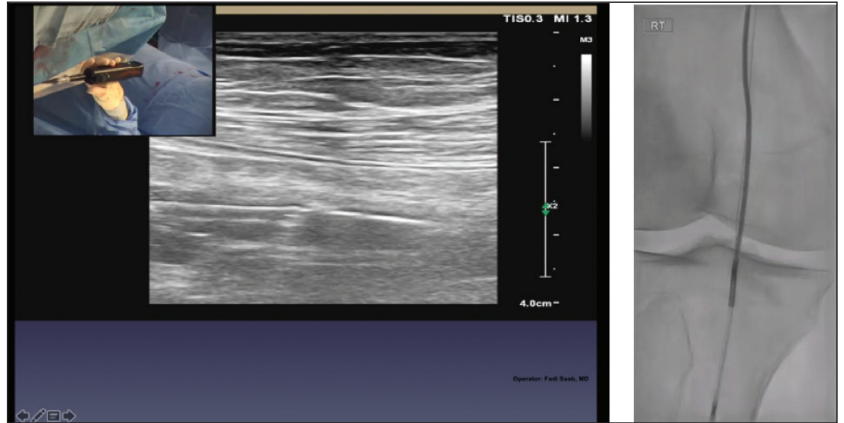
Fluoroscopic and extravascular ultrasound images of the SilverHawk DS directional atherectomy system in the tibial artery.
